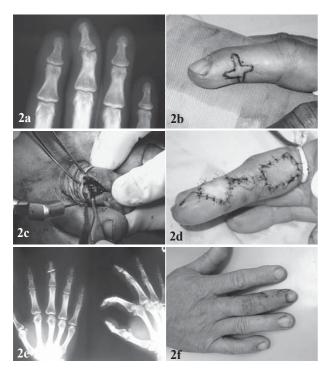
(a) Traumatic distal phalanx condyle defect. (b) Scar contracture on the distal interphalangeal joint of the right middle finger. (c) Osteochondral autograft obtained from the proximal phalanx of the right second toe. (d) Soft tissue defect covered with a reverse homodigital island flap. (e) X-ray of the hand following surgery. (f) Follow-up picture two months after surgery.
